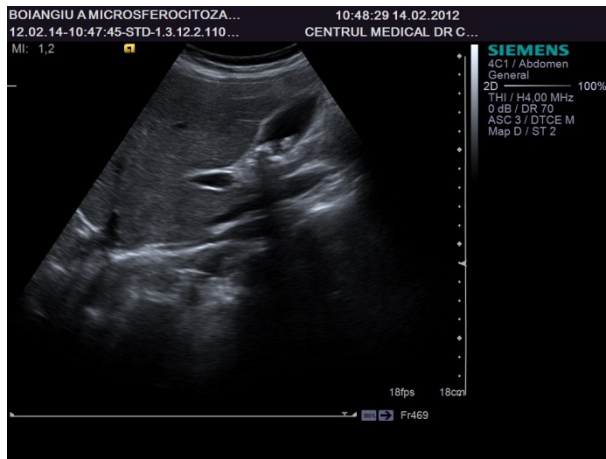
Ultrasonography showing gallstones.
